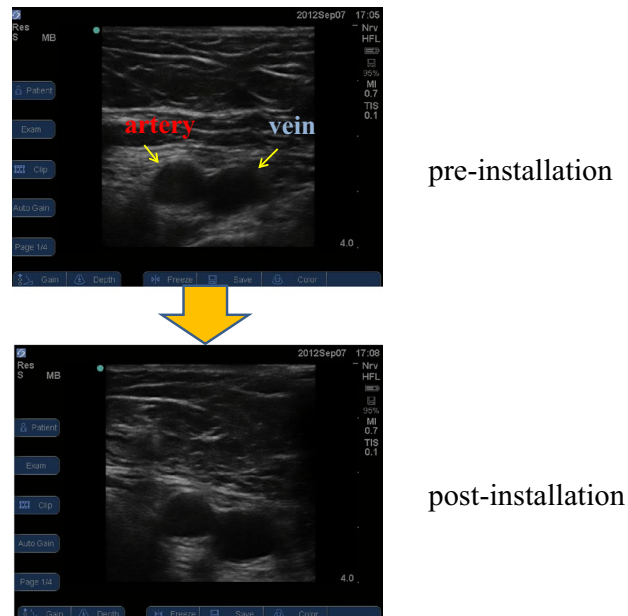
Ultrasound images of the femoral vein and artery; changes in the vascular diameter of the femoral vein when a disposable wound retractor and abdominal retractors are installed in the surgical field are shown. In this case, the diameter expanded from 10 mm pre-installation to 13 mm post-installation.
